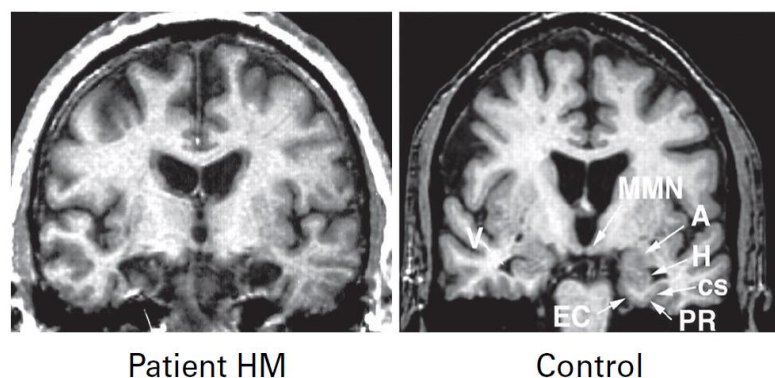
Comparison of MRI scans between patient HM and control. The right scan presents the structures before they were removed or became missing after patient’s surgery: hippocampus (H), entorhinal cortex (EC), perirhinal cortex (PR), amygdala (A), medial mammillary nucleus (MMN), collateral sulcus (cs) and ventricle (v). The left scan, therefore, shows the absence of these structures. Adapted from [54].
